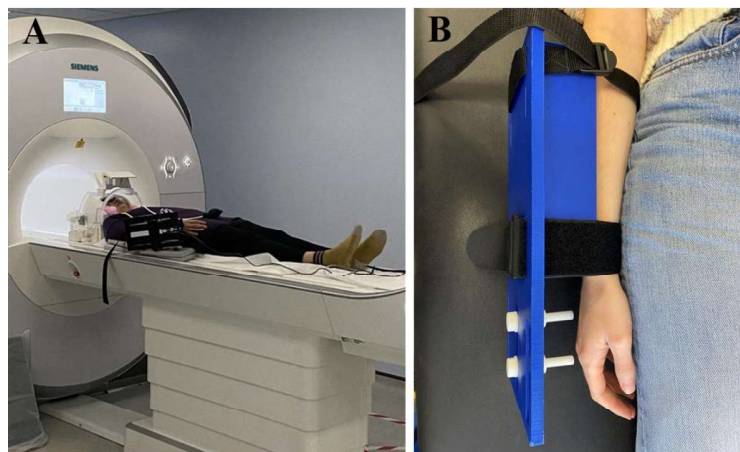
Experimental set-up and participant positioning for the MRI-compatible wrist extension ergometer. Panel A depicts the experimental set-up of the positioning of the participants in the MRI scanner with the MRI-compatible ergometer attached to their right forearm. Panel B shows a close-up of the positioning of the MRI-compatible wrist extension ergometer on the forearm.
